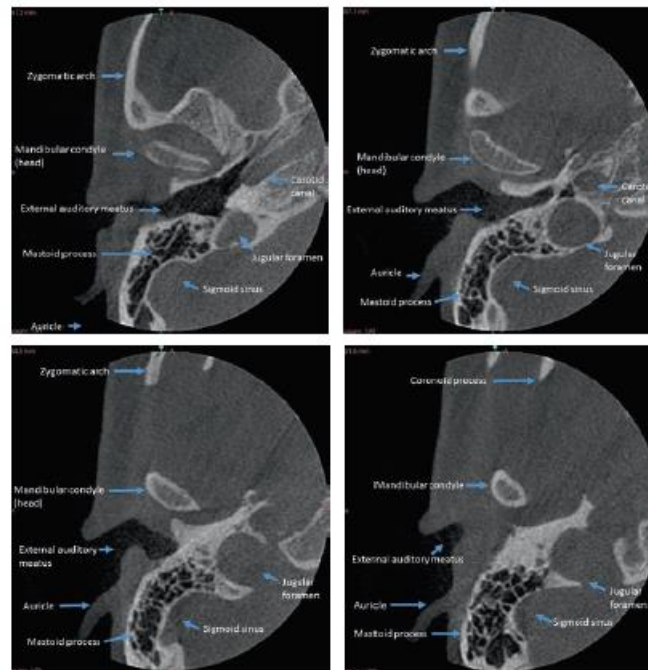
(a–d) Radiological anatomy of the TMJ in CBCT—axial slices. [40]
